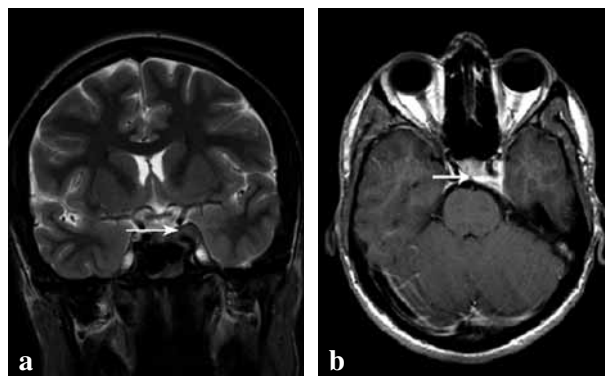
Patient 10, brain MRI: (a) coronal T2 weighted sequence showing isointense lesion in the left cavernous sinus (arrow); (b) the lesion shows strong enhancement after gadolinium enhancement on T1 weighted sequences, transverse section (arrow).
